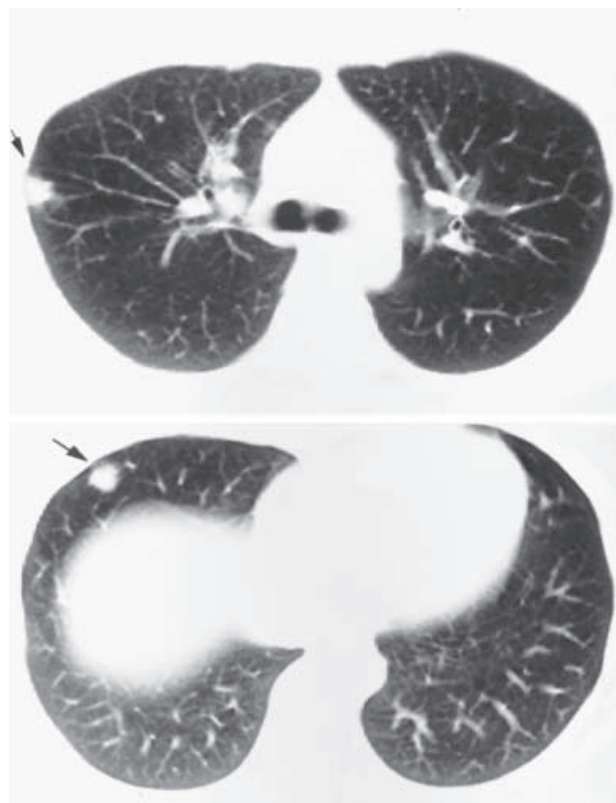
Chest computed tomography (CT) scan reveals nodular pulmonary lesions but does not detect obvious interstitial shadows (arrows)
